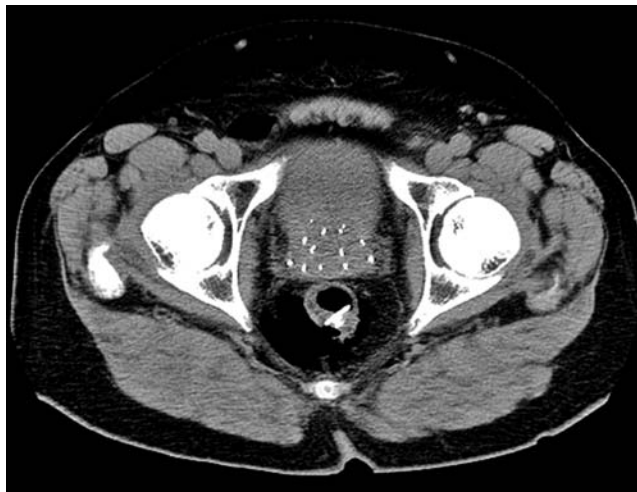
CT scan on day 1 showing a full-thickness posterior rectal perforation with free air extending to the retroperitoneal space.
